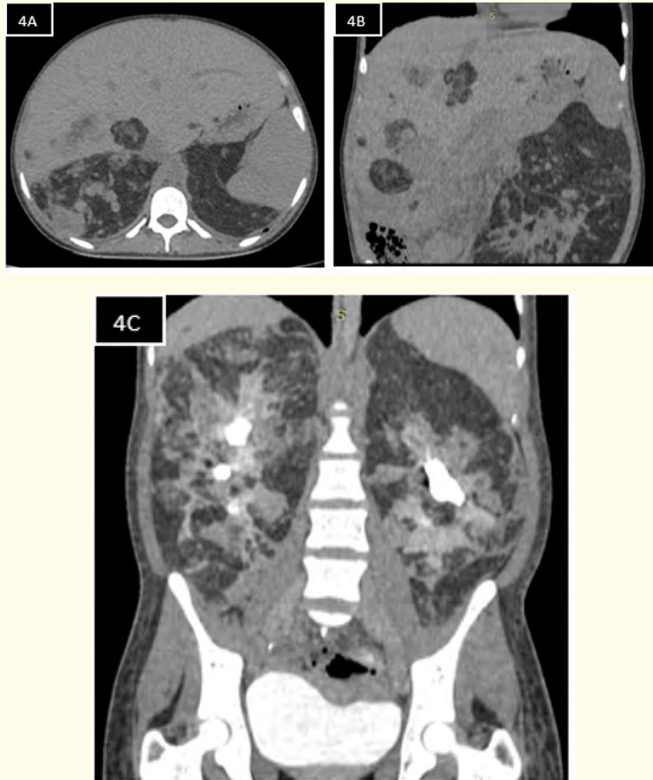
Abdominal CT findings associated with pulmonary lymphangiomyomatosis. A) Abdominal CT in axial section and single phase showing a lesion with a predominance of size at the level of the right hepatic lobe with attenuation coefficients of -70 HU and B) seen in coronal section. C) It can be seen that both kidneys concentrate and excrete the intravenous contrast medium, appreciating contrast in the urinary bladder.
